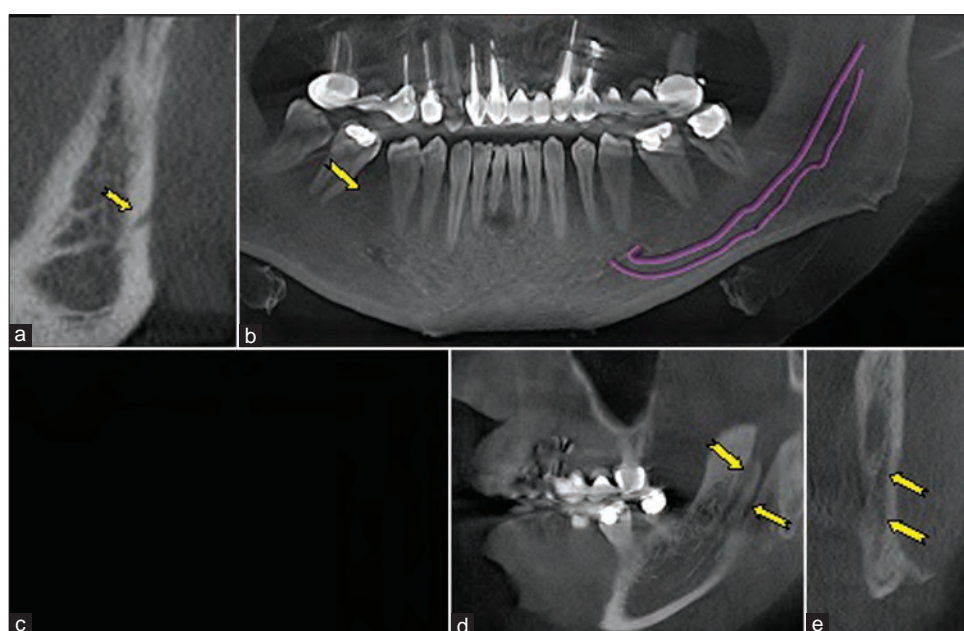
CBCT images of left mandibular canal, a, b: cross-sectional image, c: panoramic view, d: lateral sagittal, e: coronal view. In the left side, two mandibular canals including two mandibular nerves opened to two mental foramens
